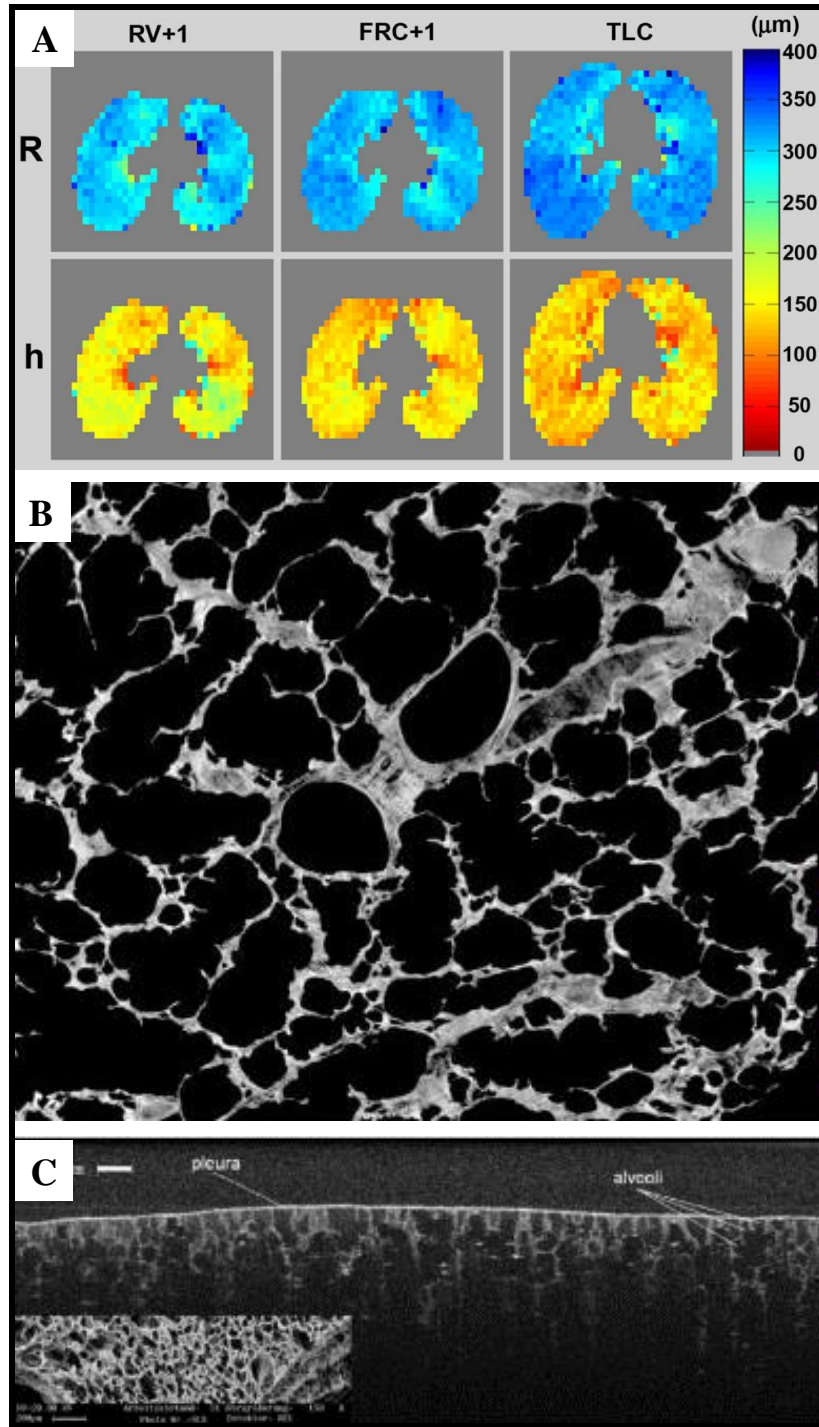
Imaging based assessment of acinar structure. Figures A, B and C show examples of images acquired using MRI, Synchrotron CT and Optical Coherence Tomography techniques respectively.
